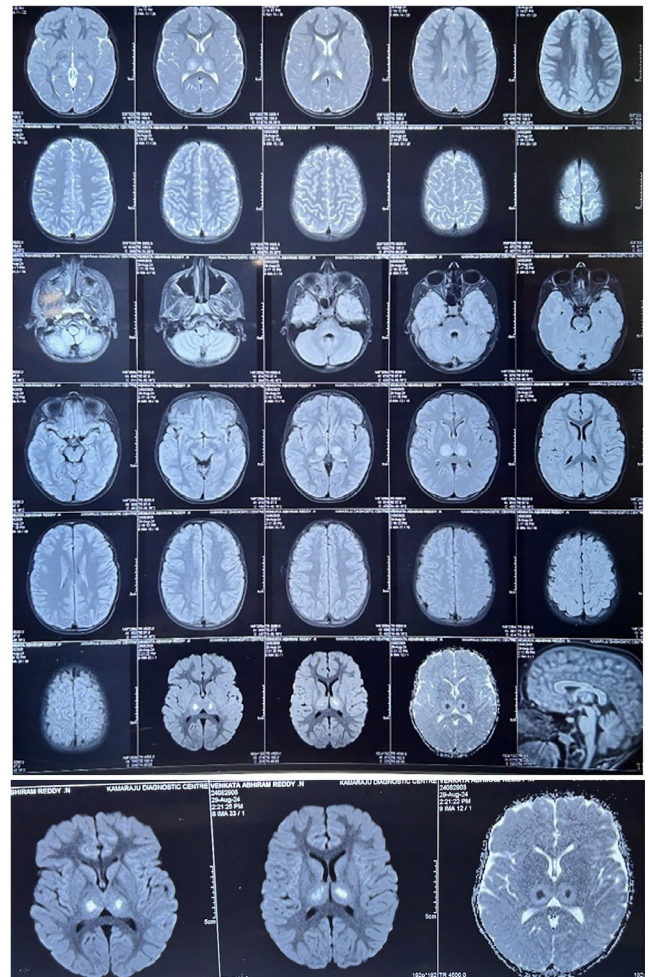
Bilateral relatively symmetrical areas of T2, FLAIR hyperintensity, T1 hypointensity with small areas of diffusion restriction in thalami
